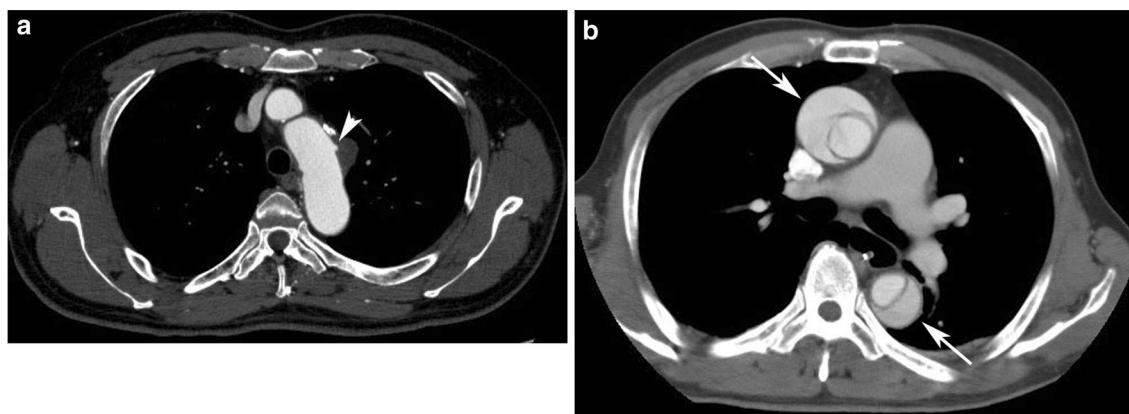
CT scan of patients with penetrating atherosclerotic ulcer (a) and aortic dissection (b) at the level of aortic arch and ascending aorta, respectively. A contrast-filled penetrating atherosclerotic ulcer
